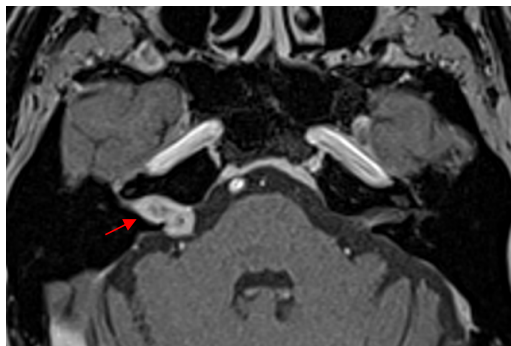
Contrast-enhanced T1-weighted MRI, axial view, demonstrating a vestibular schwannoma located in the internal auditory canal and protracting to the cerebellopontine angle, koos grade II.
